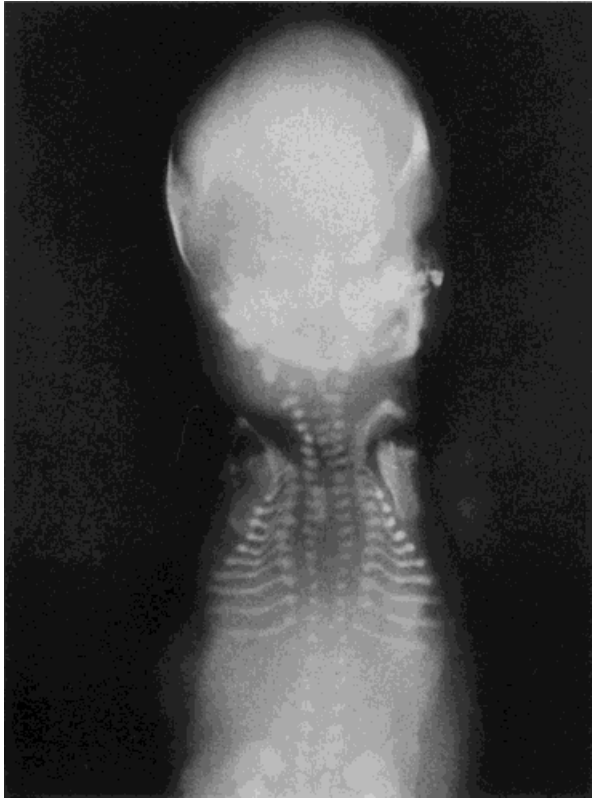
Radiographic features of the cranium and thorax.
